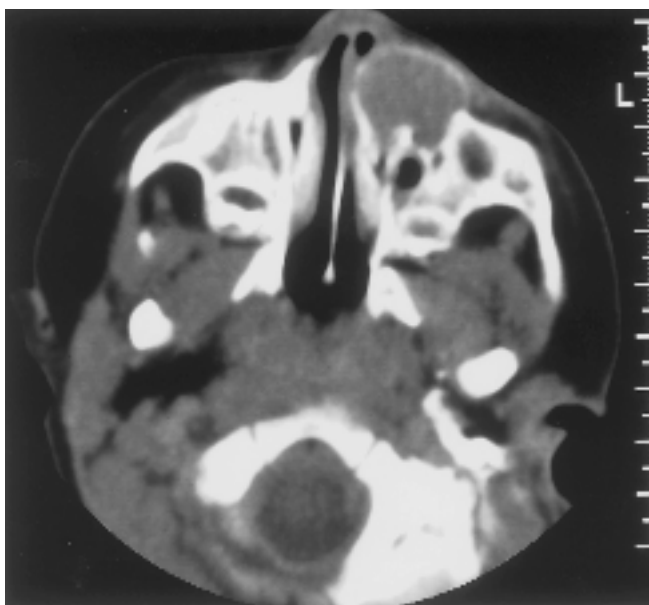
Axial CT scan showing a non-enhancing expansile lesion in anterior aspect of left maxillary sinus.
